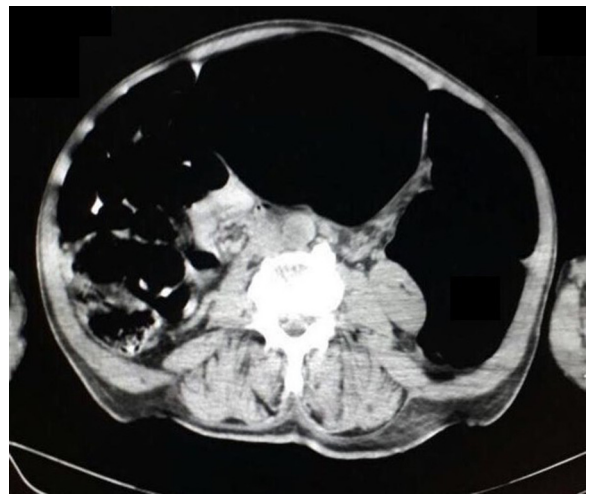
CT Abdomen showing a Sigmoid Volvulus with Steel pan pattern.
